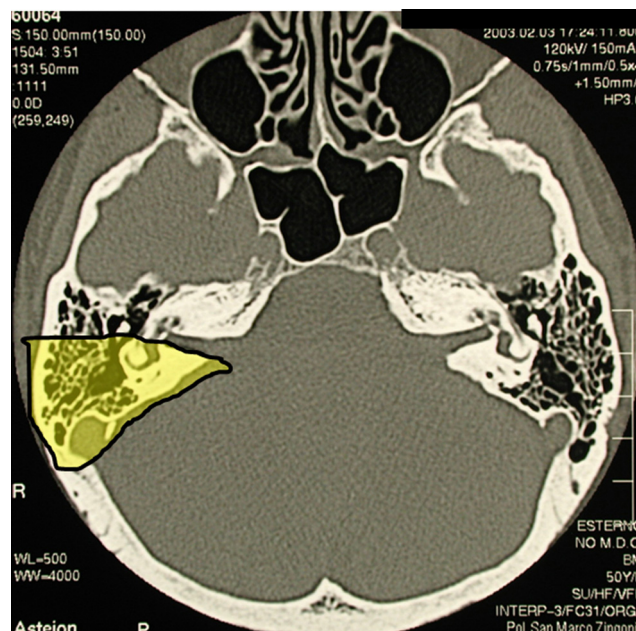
Axial CT bone window of the skull base showing extent of bone removal using the translabyrinthine approach to the cerebello-pontine angle (yellow area).
